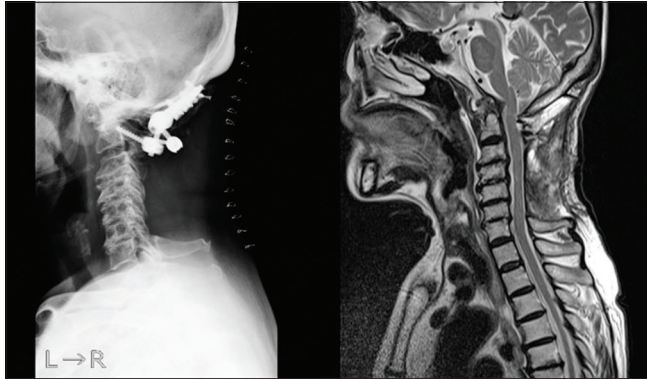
Postoperative Xp demonstrating C1-C2 fusion and MRI demonstrating resolution of retro-odontoid cyst.
